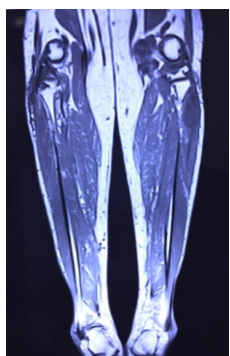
Hypointense signal in proximal peroneus longus on T1 coronal sequence of MRI
